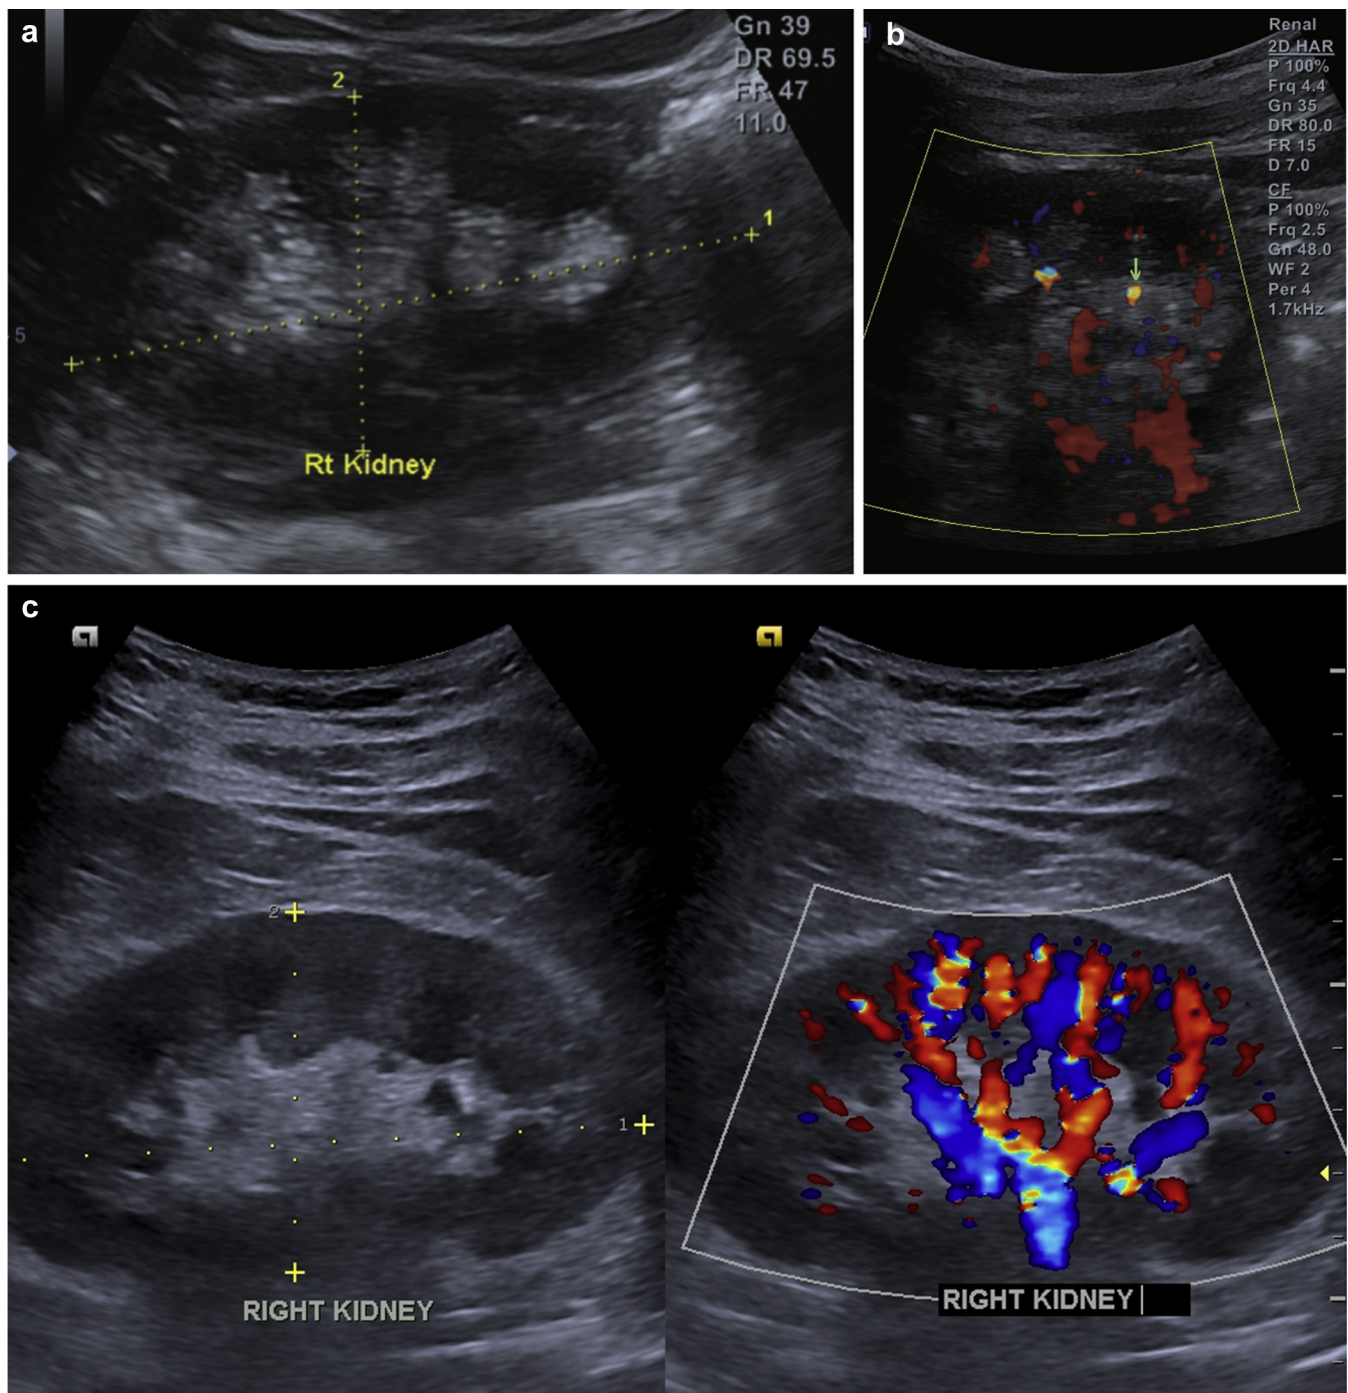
(a) Diffuse hyperechogenicity of renal medulla on B-mode ultrasonography. (b) Color doppler ultrasonography showing numerous twinkling artifacts (green arrow). (c) Ultrasonographic image of a normal patient. Note that the renal medulla is hypoechoic as compared to the cortex on B-mode scanning, and there is no twinkling artifact on color Doppler. Rt, right.
